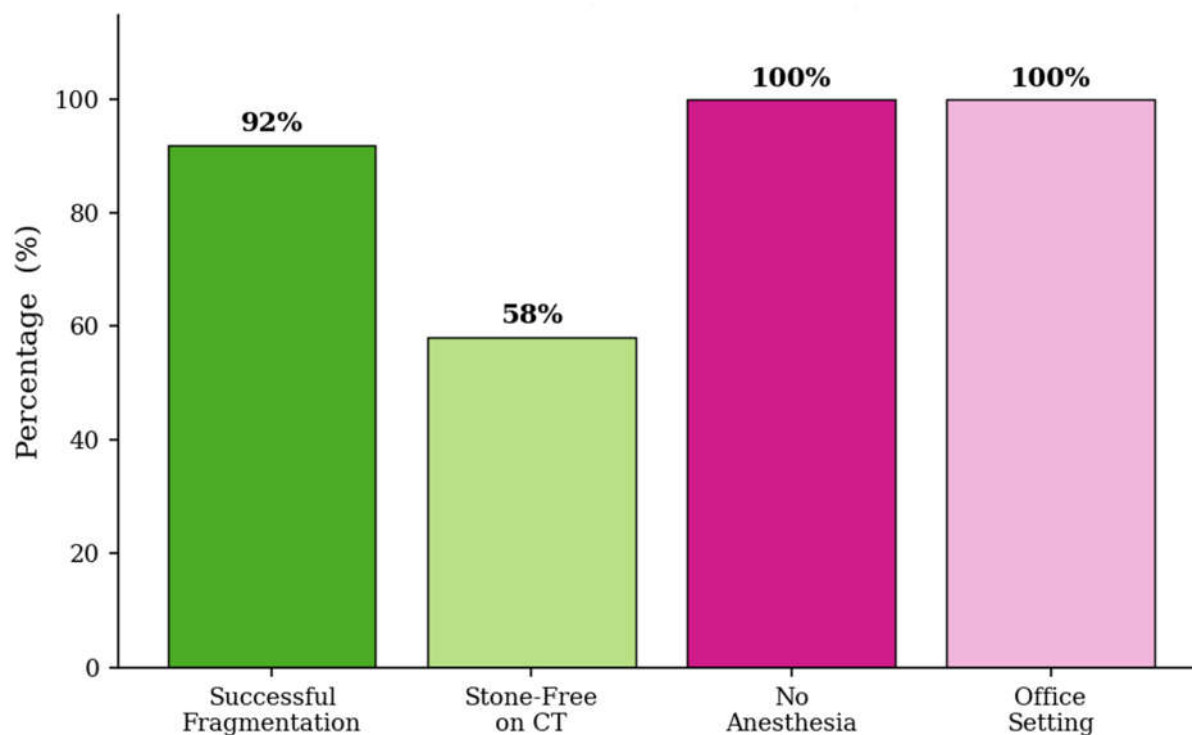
reak Wave Trial (BWL) outcomes: 92\% successful stone fragmentation, 58% stone-free on follow-up CT, and the ability to be performed in an office setting without anesthesia.
